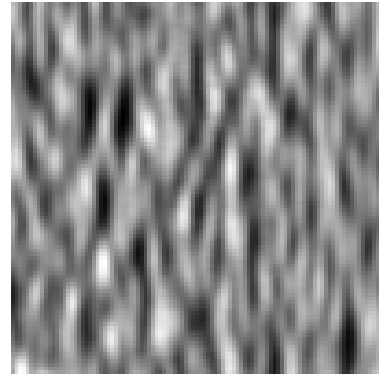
A typical ultrasound B-mode image. Each row of this image is an envelope A-line signal similar to the one shown in Fig.1.2
